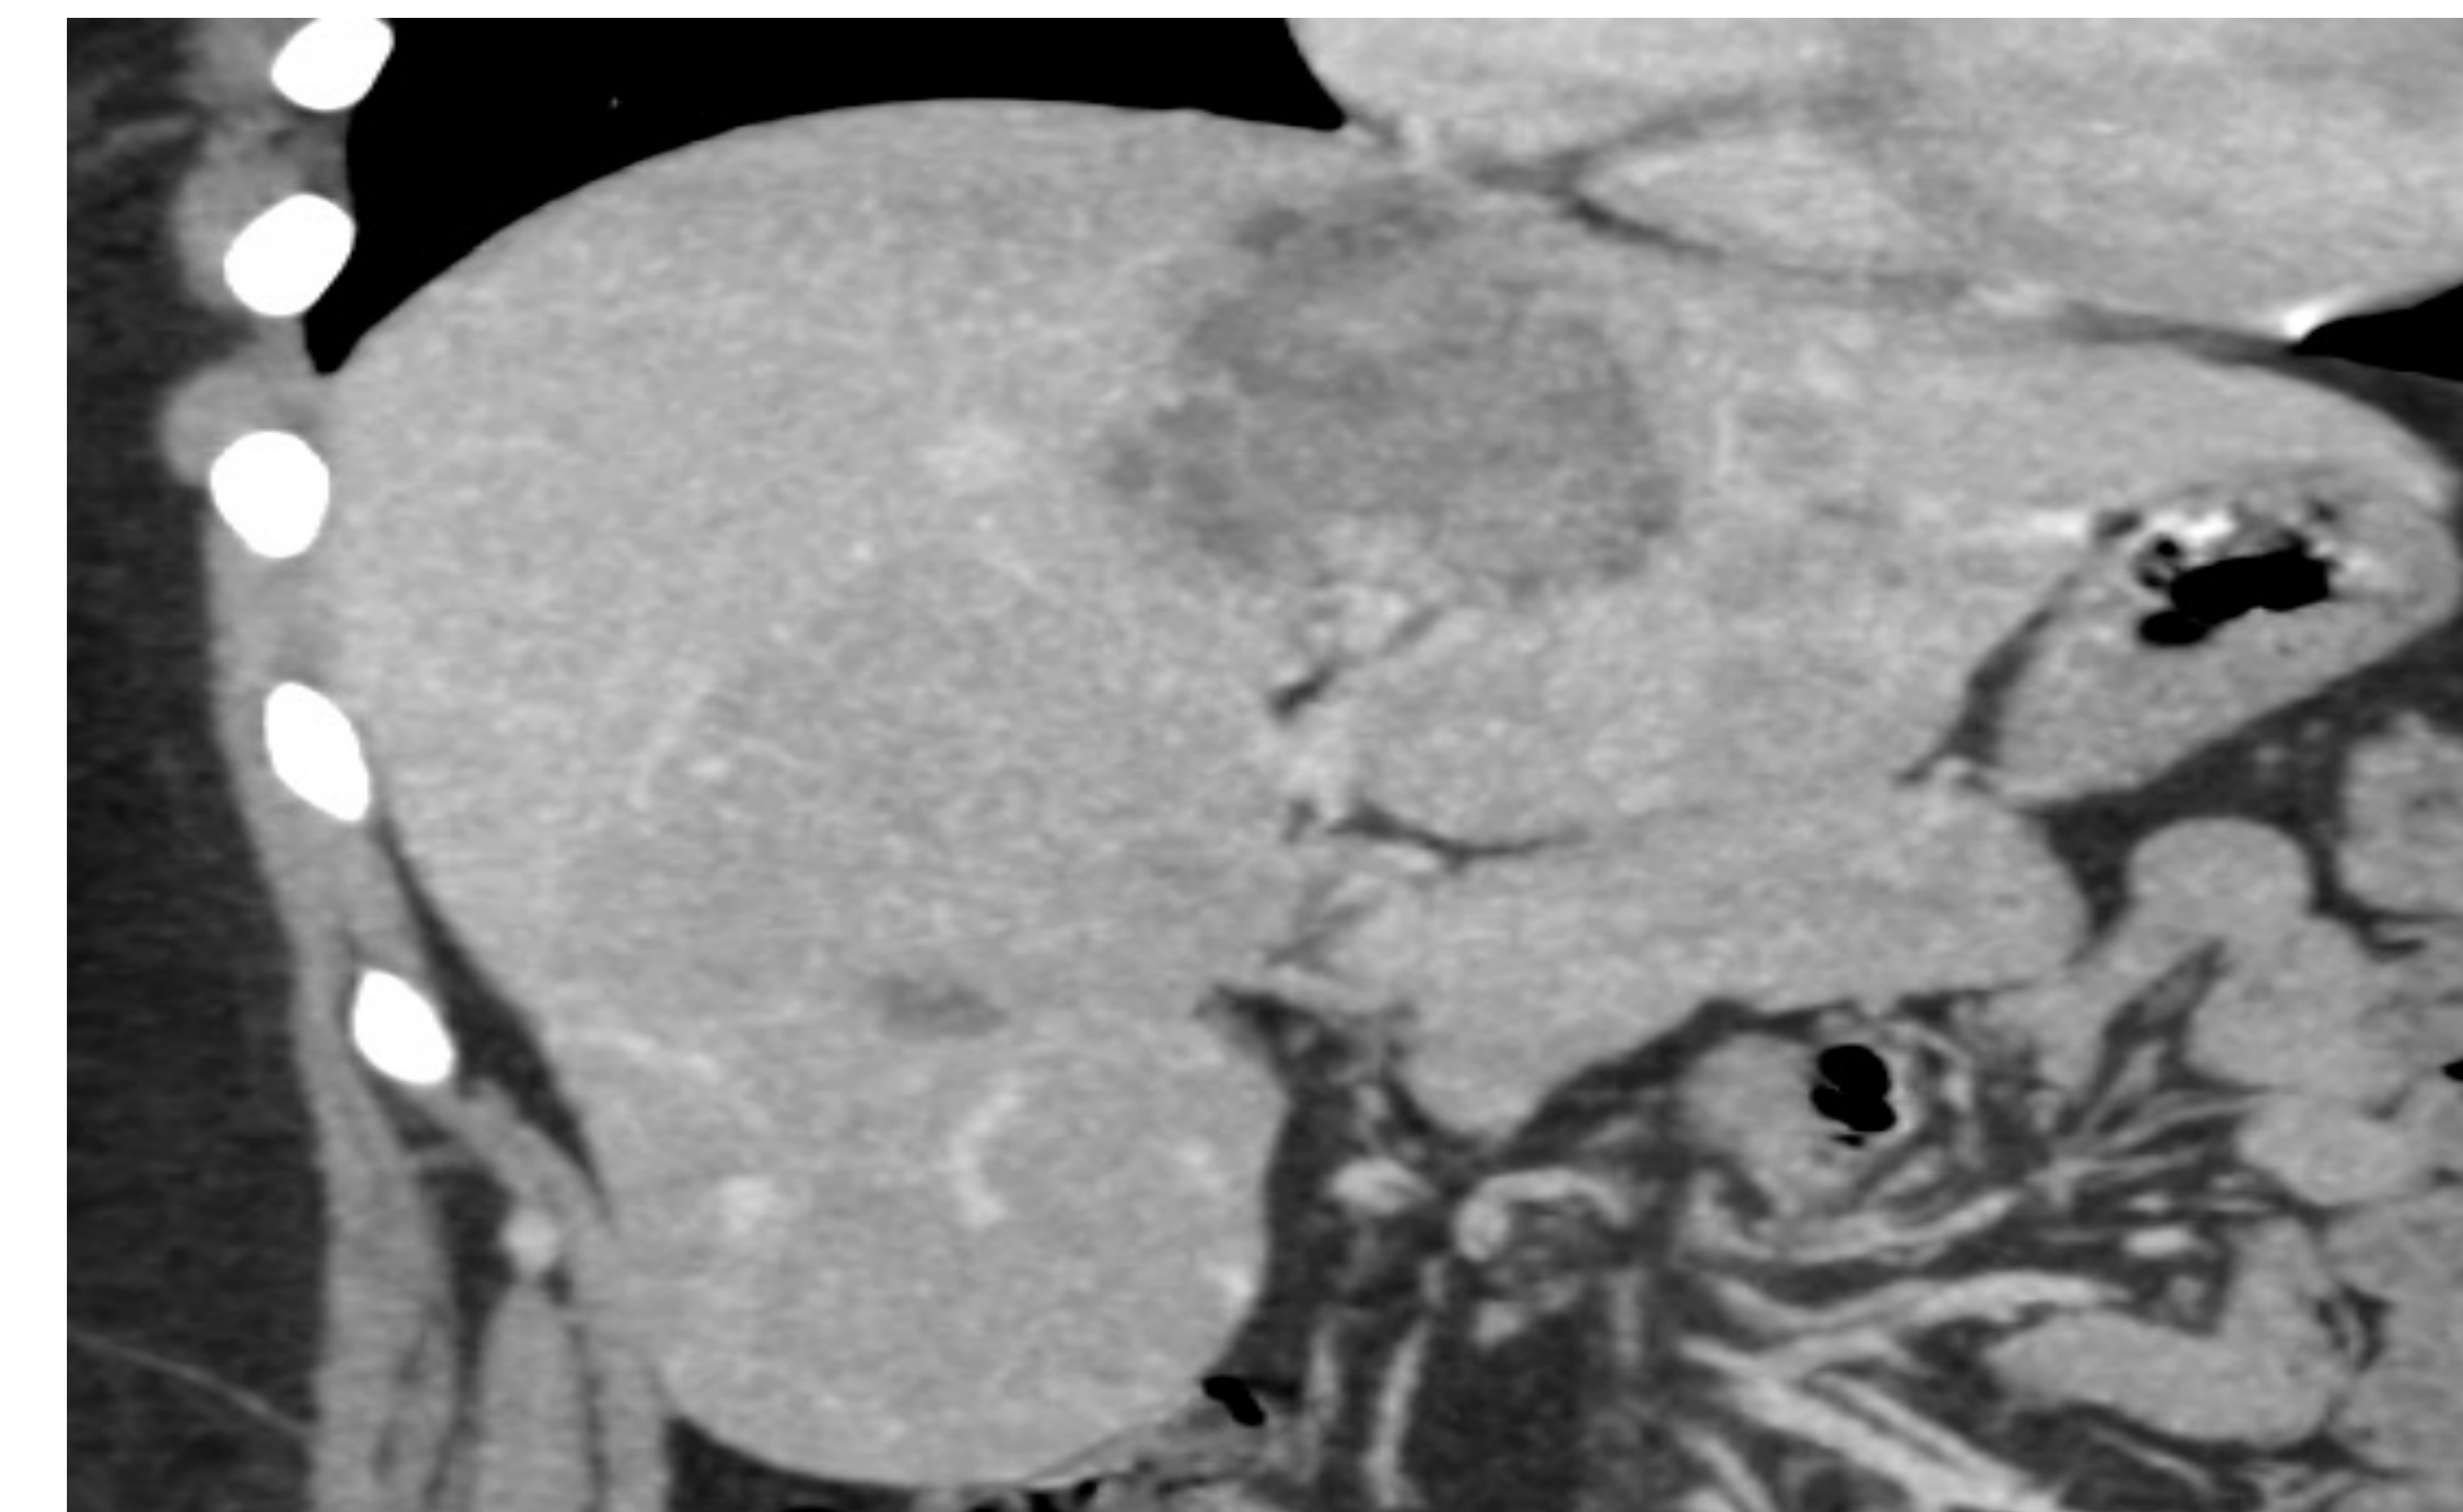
CT Liver with HCAs
